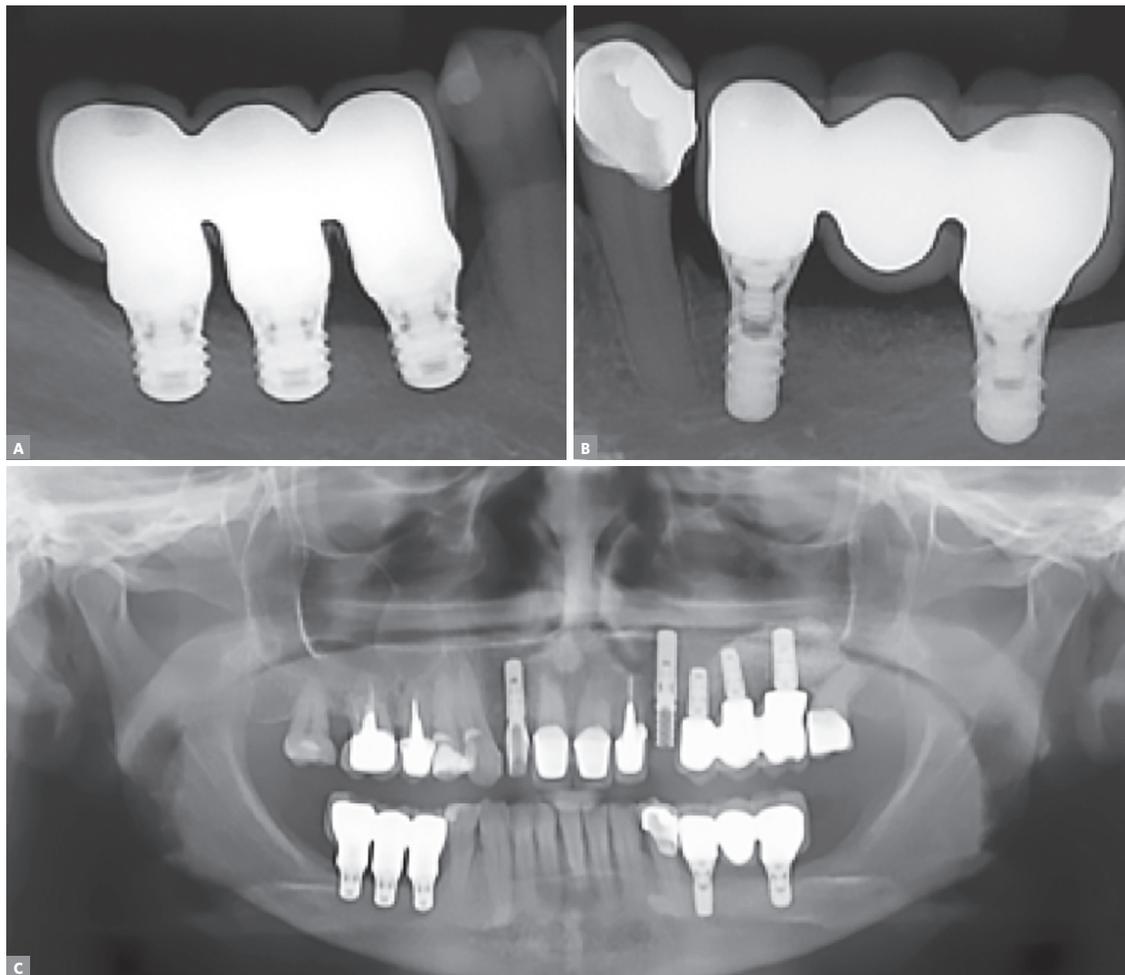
1-year-follow-up periapical and panoramic radiographs revealing stability of peri-implant tissues, proper prosthetic fitting and crown-implant ratio.
